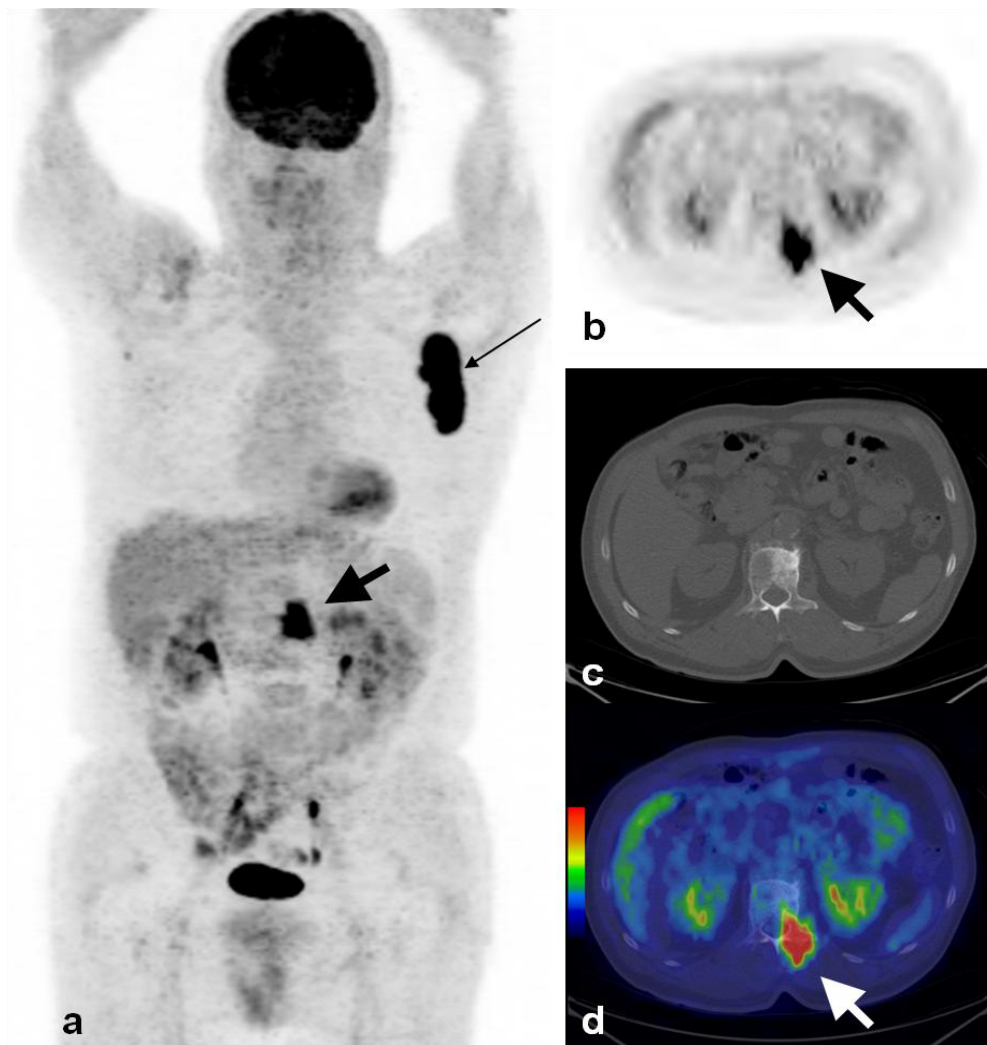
PET/CT performed for staging of MCC
